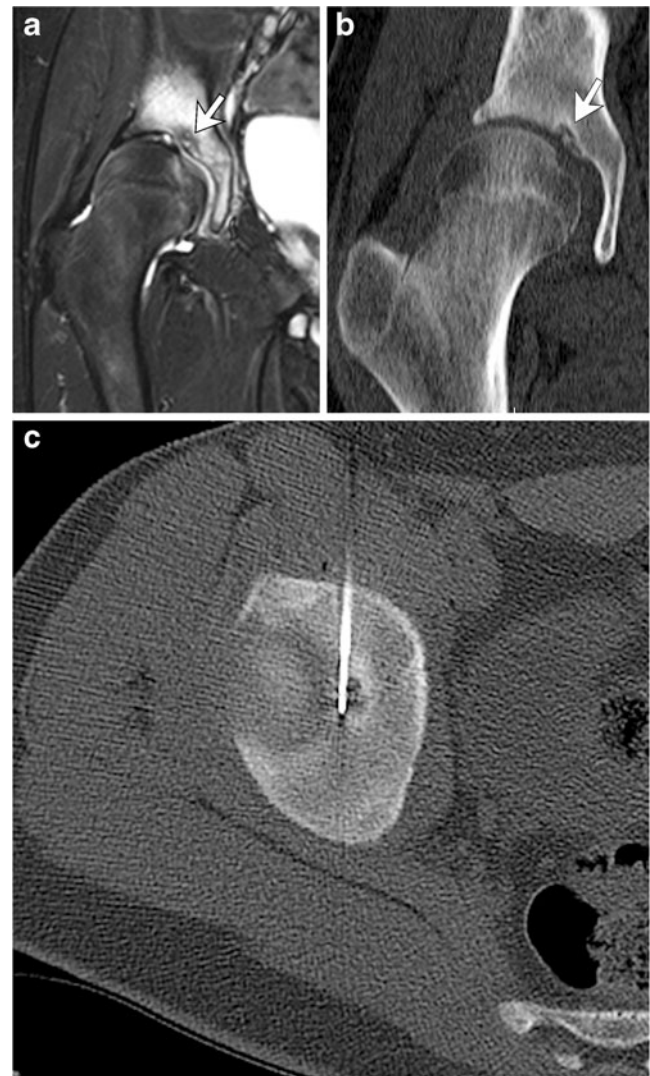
Osteoid osteoma within the right acetabular roof in a 13-year-old boy with 2 months of right hip and thigh pain. Hip contracture on examination. a Coronal fat-saturation T2 image of the right hip shows extensive edema within the right acetabulum with a focal lesion within the right acetabular roof with surrounding hypointense rim (arrow), suggesting an osteoid osteoma. Noted is a small joint effusion. b Coronal reformatted CT image shows the lucent lesion within the acetabular roof with a central nidus and thin rim of sclerosis (arrow). This lesion is surgically inaccessible and radiofrequency ablation is the preferred treatment option. c Axial CT image during radiofrequency ablation demonstrates placement of the electrode tip within the lesion, which is in close proximity to the acetabular articular cartilage
